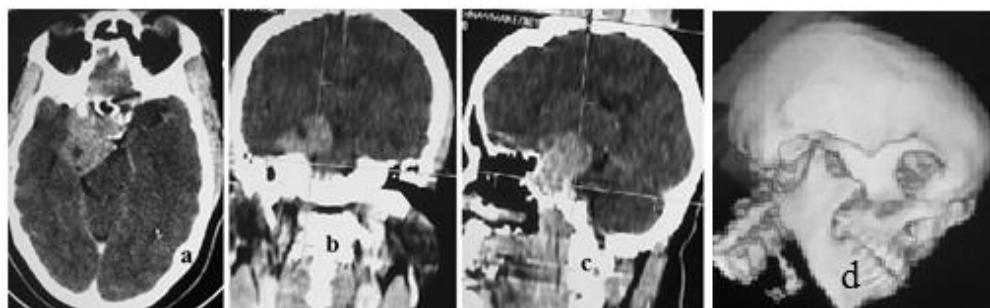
CT images of a parasellar mass. a. Axial section. b. Coronal, c. Sagittal and d. Surface reconstructed images for three-dimensional localisation of the tumour mass and skull bones.
